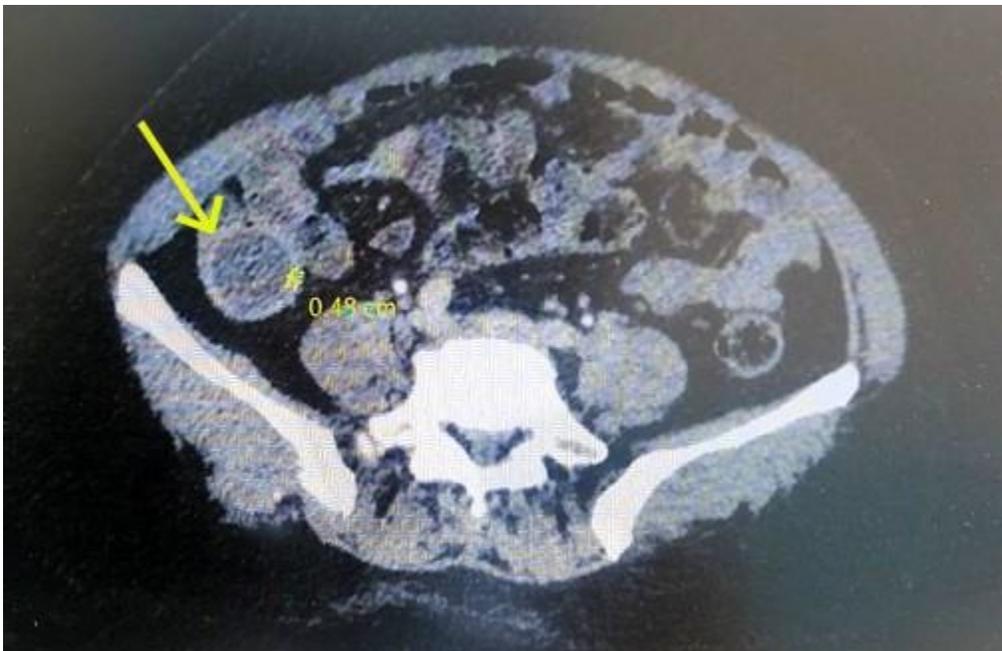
CT findings- cystic-like structure with a thickened enhanced wall (0,48cm).
